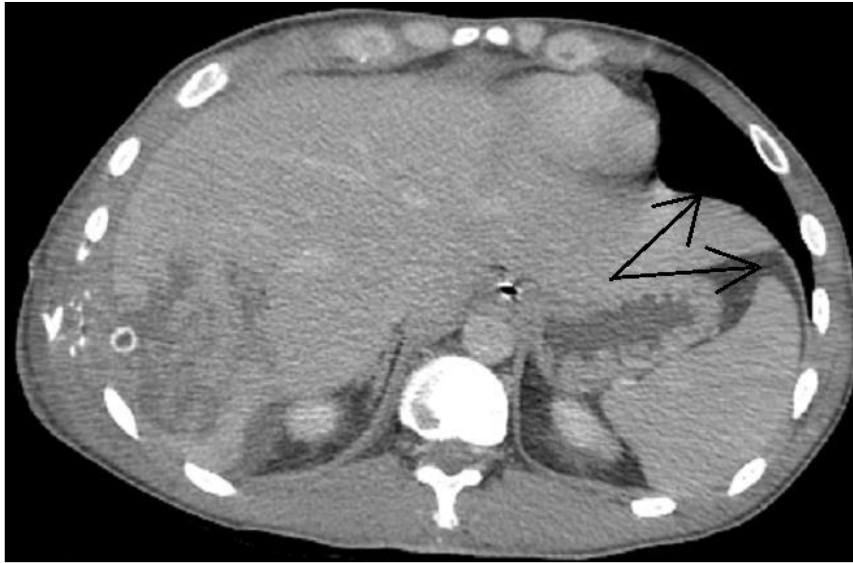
CT scan of abdominal organs, axial projection. Penetrating gunshot (shrapnel) injury to the abdominal cavity, injury to the right lobe of the liver, hemopneumoperitoneum (arrows).
